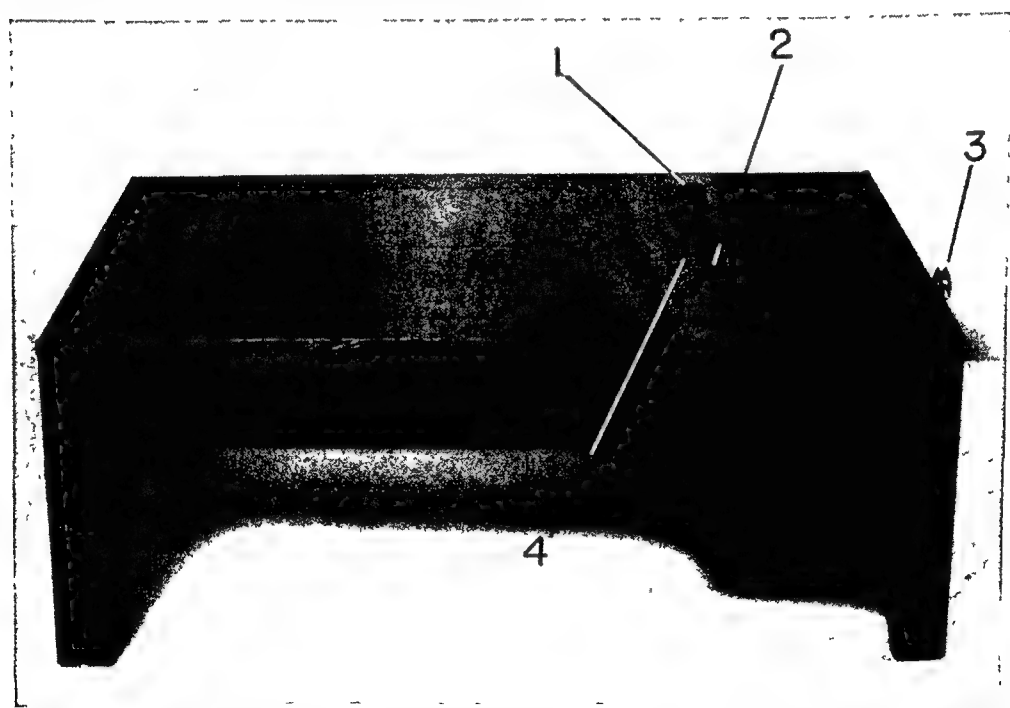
ORTHO-X-POSER—FOOT X-RAY EXAMINATION STAND *Structural Features* (1) Radiation-proof well to protect film in lateral exposures. Provision for ray to under-cut foot. (2) Cassette engaging bar holds film-holder in fixed vertical position. (3) Pull-knob used to engage bar against film-holder. (4) Foot position scale in one inch gradations, in front of film well, insures duplication of film position for stereoscopy. Guide lines are present on front of device to assist in positioning central ray. Fixed depth of protection in well equal to one-half the 10 in. dimension of either 8 in x 10 in or 10 in x 12 in exposure holder. Cassette holder for vertical or horizontal position. Durable cabinet to withstand hard clinical use with patients of maximum weight. Easy to mount—11 in high (Ritter Co Inc)
